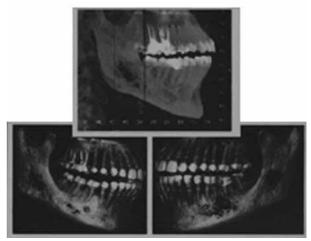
Panoramic radiography examination revealed a moth-eaten shape, and radiolucent appearance.
